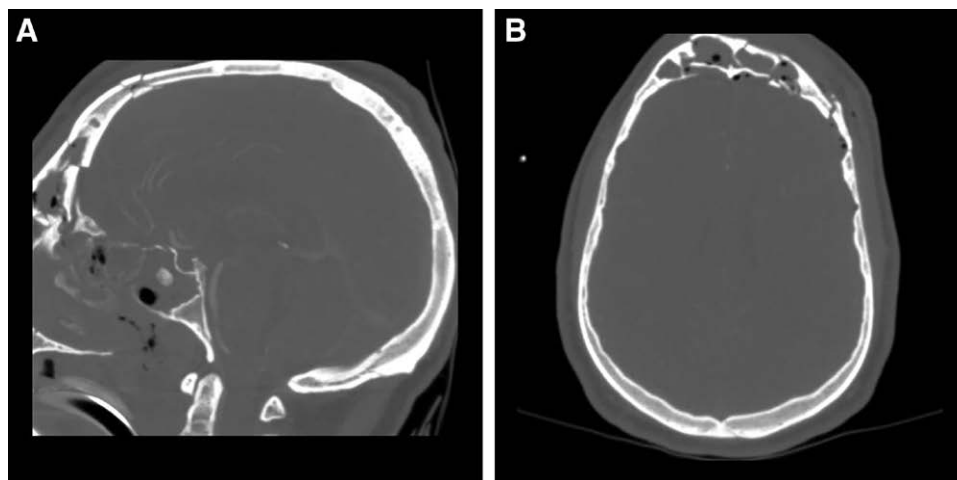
CT image of severe comminuted anterior table and posterior table fracture. A, Sagittal view. B, Axial view. Published with permission from and copyrights retained by Eduardo D. Rodriguez, MD, DDS.
